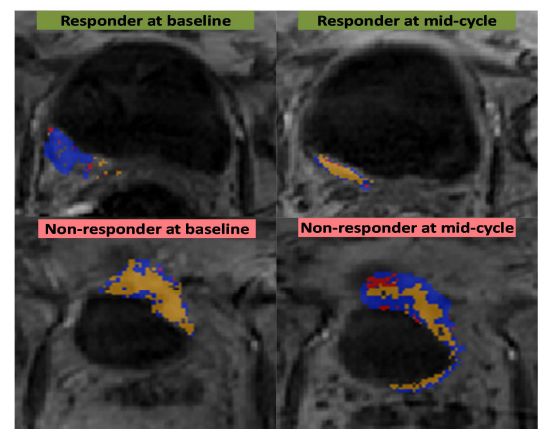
Cluster display on MR images (a 72-year old male (upper row) and a 54-year old male (lower row)).
